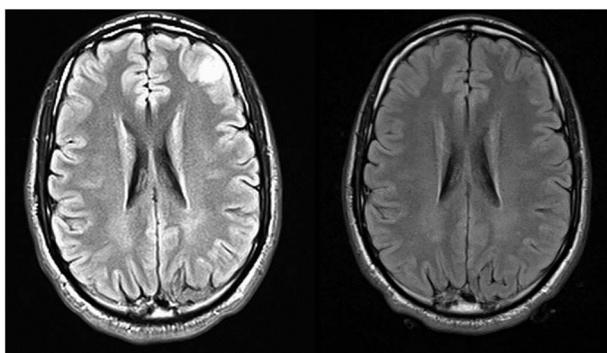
A T2 FLAIR brain image in axial views from baseline (left) to 1-year follow-up (right). An 8 × 11 millimeter scolex, peripherally enhancing, and cortically based lesion with adjacent vasogenic edema in the left middle frontal gyrus most consistent with a vesicular form of neurocysticercosis. MRI of the brain in radiological view (i.e., left is right and right is left).
